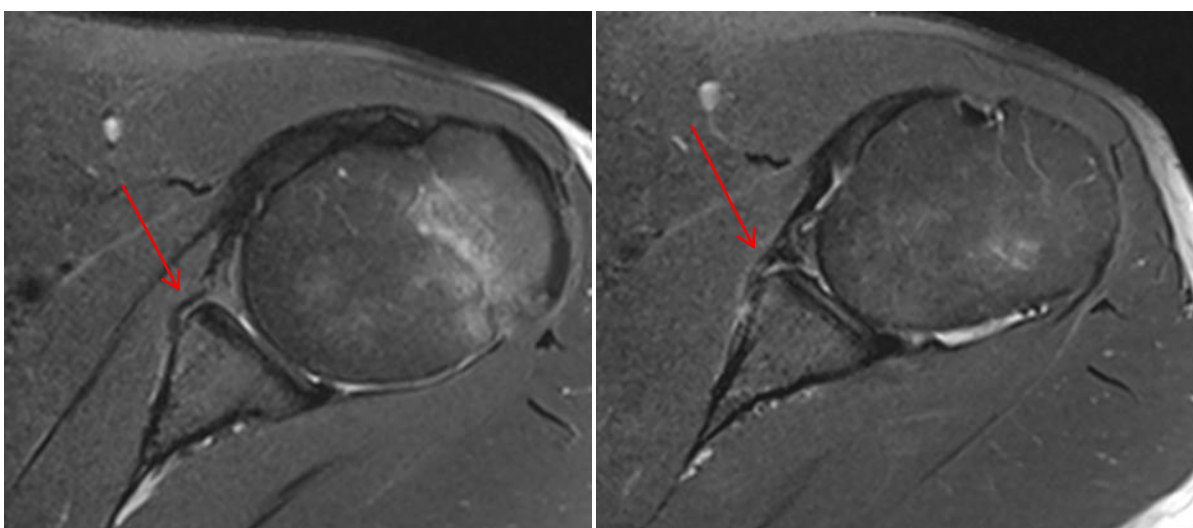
Above PD FAT SAT MR images show detachment of the antero'-inferior labrum (3-6 o'clock) with medially stripped but intact periosteum – Perthe's injury (red arrows)
